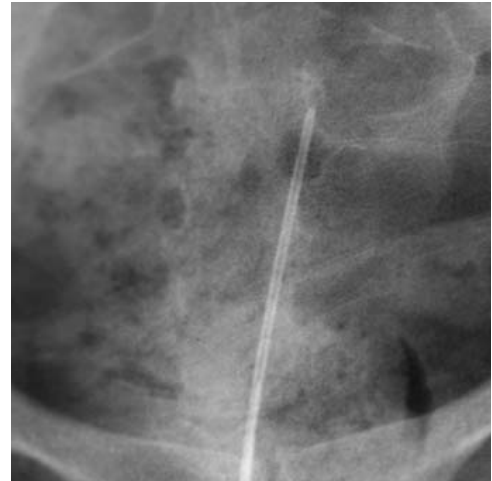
SCOUT RADIOGRAPH OF THE PELVIS
